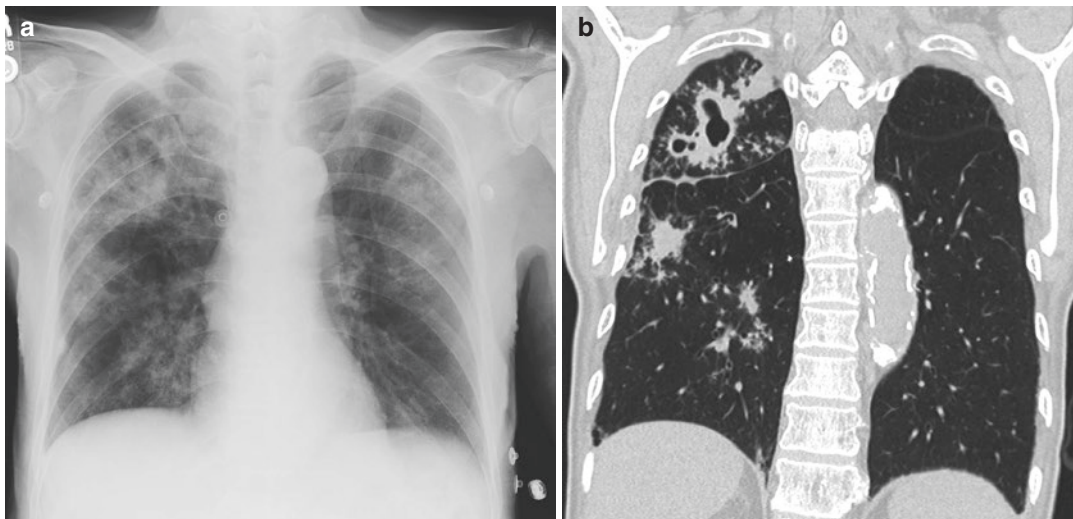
Frontal radiograph (a) and coronal CT chest (b) in a 79-year-old male with right upper lobe thick-walled cavitary structures found to have reactivation TB
